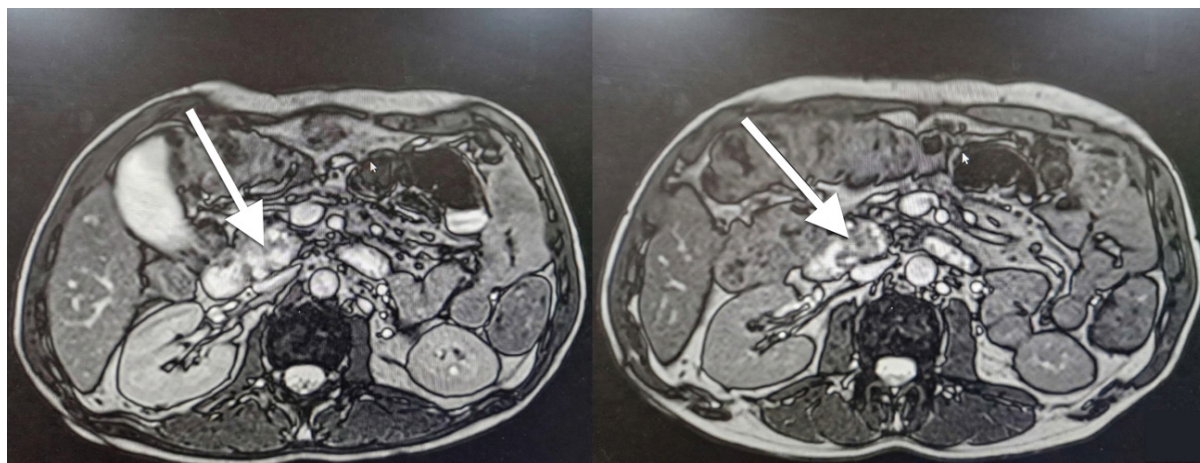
CT of the first patient depicting the new lesion. White arrow showcasing the presence of the lesion on the pancreatic head.
